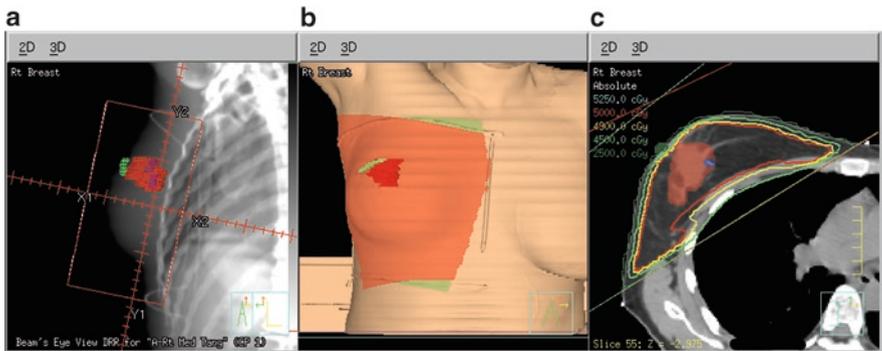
Field boundaries for a 41-year-old woman with a pT1b, N0 (sn), M0 estrogen- and progesterone-receptor-positive invasive ductal carcinoma of the right breast who underwent lumpectomy and sentinel node biopsy and was receiving tamoxifen. Postoperative whole breast radiotherapy was planned to complete breast-conserving therapy. (a) Medial tangent digitally reconstructed radiograph with the tumor bed and surgical clips demarcated and at least a 1.5-cm margin around the tumor bed and surgical clips posteriorly with approximately 1.5–2.0 cm of lung in the field. (b) Skin rendering of the medial and lateral tangential beams demonstrating the standard field boundaries (the midaxillary line laterally, the mid sternum medially, just below the clavicular head superiorly, and approximately 2 cm below the inframammary fold inferiorly). (c) Axial view of the treatment plan demonstrates the coplanar posterior field edges used to minimize exit dose into the lung parenchyma
